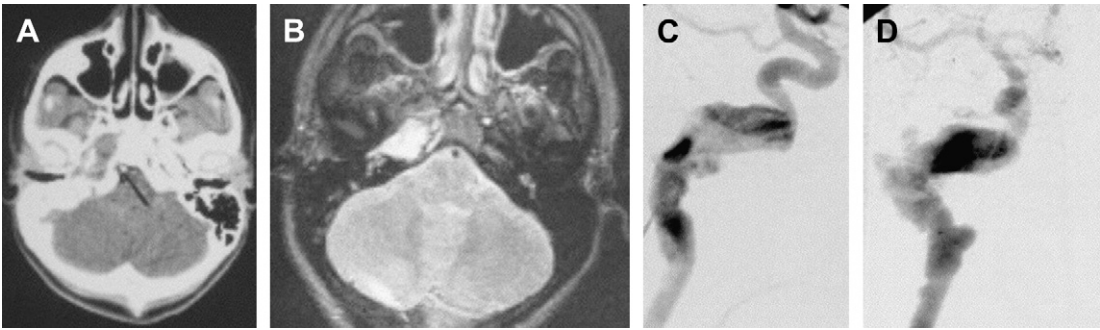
Traumatic aneurysm. A 15-year-old girl presented with right-sided pulsatile tinnitus and a vascular mass behind the right tympanic membrane 3 years after a motor vehicle accident in which skull base fractures were sustained. A nonenhanced CT (A) and T2-weighted MRI (B) demonstrate a mass enlarging at the right petrous carotid canal. Catheter angiography of the right ICA in the lateral (C) and AP (D) projections confirms a fusiform dissecting traumatic aneurysm of the high cervical and petrous segments of the ICA. This lesion was treated with endovascular parent artery occlusion, with resolution of tinnitus.
